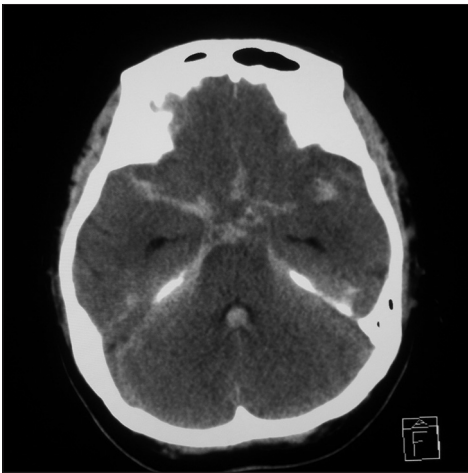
Noncontrast axial computed tomography scans taken at the onset showing diffuse subarachnoid hemorrhage
